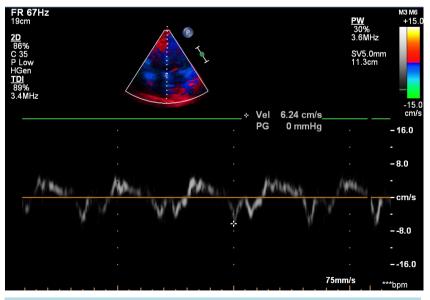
Tissue Doppler imaging of mitral annulus.
